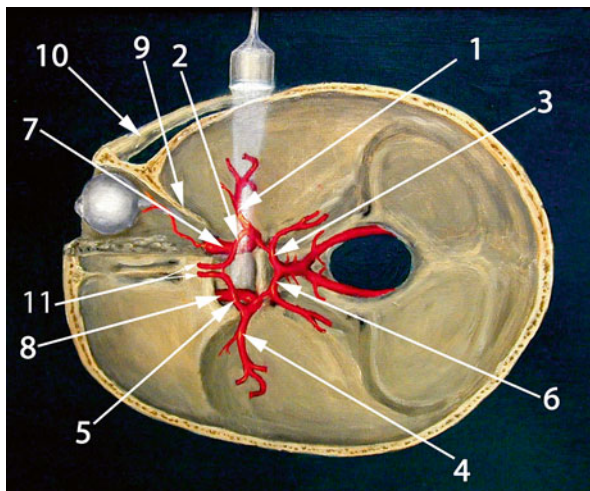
Normal anatomical distribution of intracranial arteries. Compare to Fig. 15.9, which is a duplex image of the circle of Willis in approximately the same anatomical plane with the same labeling. 1 ipsilateral MCA, 2 ipsilateral ACA A1 segment, 3 ipsilateral PCA P1 segment, 4 contralateral MCA, 5 contralateral ACA A1 segment, 6 contralateral PCA P1 segment, 7 ipsilateral ICA, 8 contralateral ICA, 9 lesser sphenoid wing, 10 zygomatic arch, 11 bilateral ACA A2 segments (This figure was adapted from http://en.wikipedia.org/wiki/File:Transcranial_doppler.jpg under the terms of GNU Free Documentation License, Version 1.3 by Rune Aaslid)
